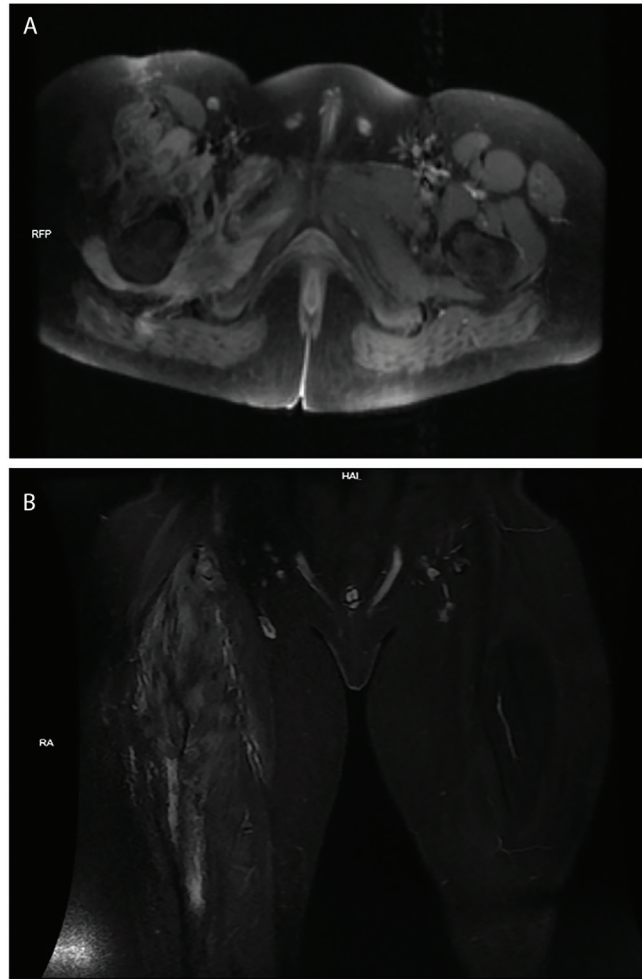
Axial T1-weighted magnetic resonance imaging (MRI) image (A) shows an inhomogeneous hypointense mass in the anterior right thigh. The lesion shows an inhomogeneous hyperintense signal on MRI coronal STIR images (B).
